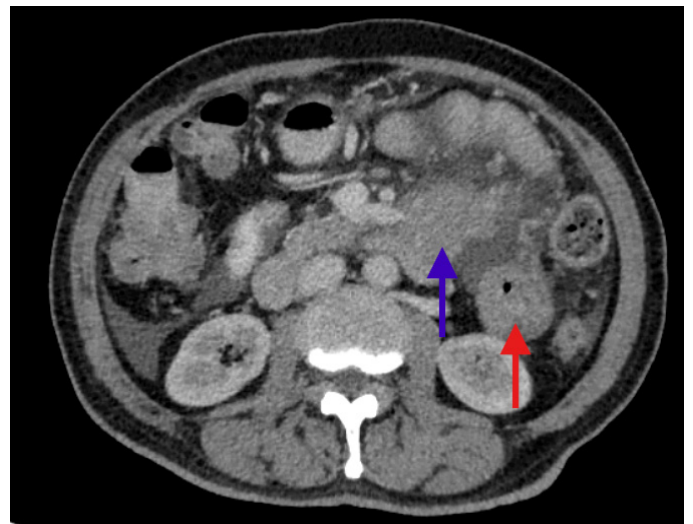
Preoperative contrast-enhanced computed tomography scan of the abdomen. The blue arrow denotes enlarged mesenteric nodes. The red arrow denotes an intraluminal heterogeneous mass at the proximal small bowel
